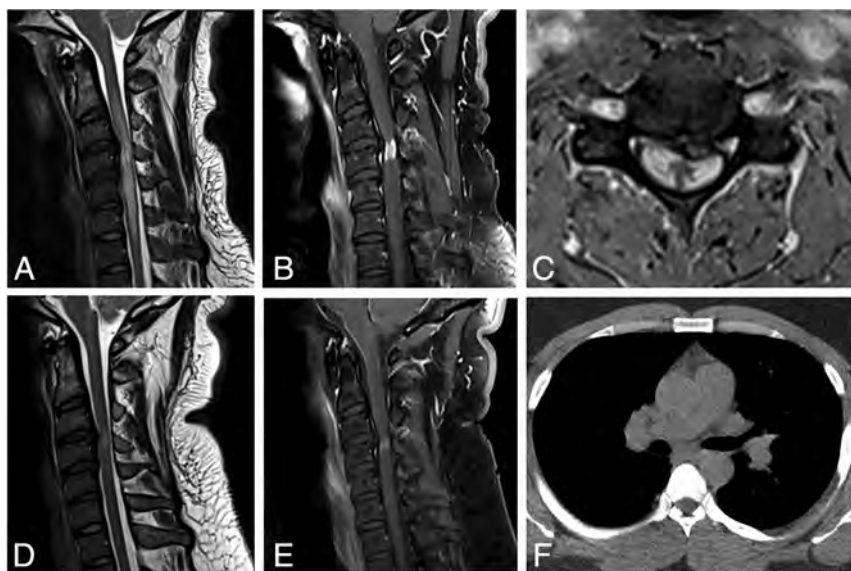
A 31-year-old man with 6 months of progressively worsening bilateral arm and leg weakness and numbness. Sagittal T2-weighted (A) image shows a prominent disc osteophyte complex at C3–4 with spinal canal stenosis and long-segment cord signal abnormality. There is focal cord enhancement centered just below the level of compression on postcontrast sagittal (B) and axial T1-weighted (C) sequences, with involvement of the peripheral cord and relative sparing of the central GM. There is persistent-but-decreased cord signal abnormality and enhancement at the 23-month follow-up on sagittal T2-weighted (D) and postcontrast T1-weighted (E) sequences. Noncontrast chest CT at presentation (F) shows bilateral hilar adenopathy.
